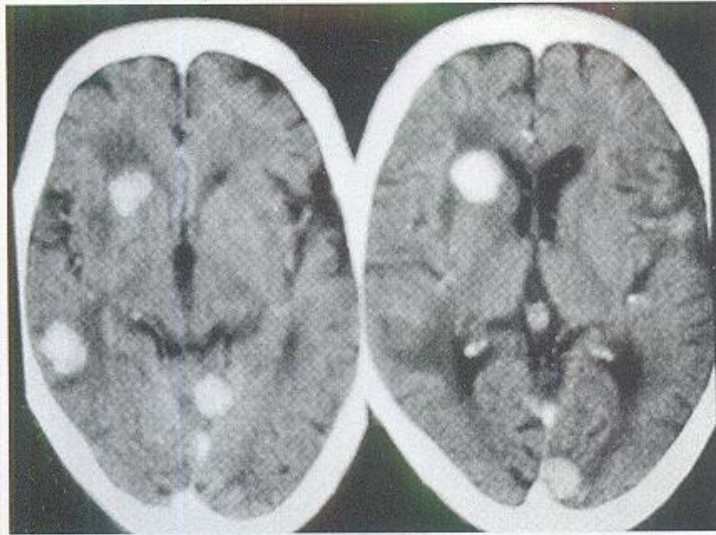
CT showing secondaries in brain. Note the multiple lesions in brain. Secondaries are the commonest malignant tumour in brain. Primary may be from breast, lungs, thyroid or sarcomas. Treatment is external radiotherapy, chemotherapy, anticonvulsants. It has got poor prognosis.
